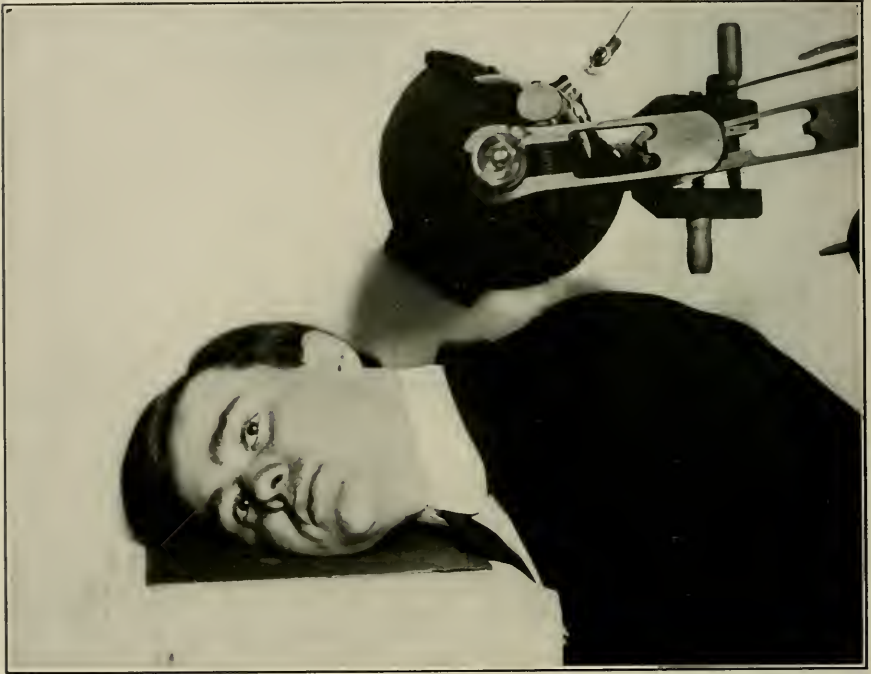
Pose for the radiograph shown in Fig. 103.
